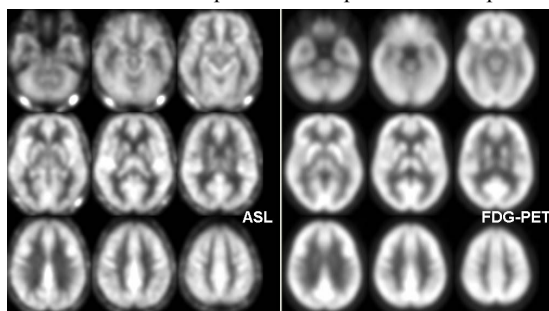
(L) mean CBF(ASL) (R) mean FDG-PET images
